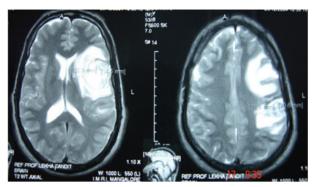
MRI T2W images showing that lesions are becoming hyperintense
